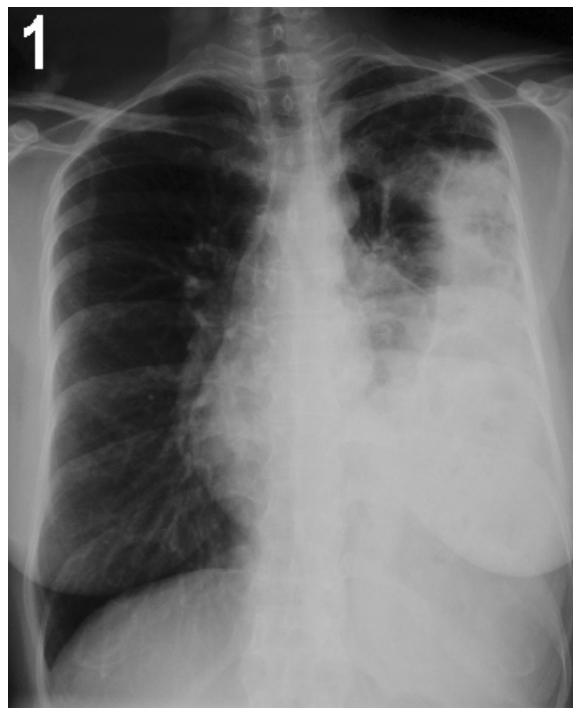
Chest radiograph PA view showing raised left hemidiaphragm and presence of air filled bowel loops in the left thoracic cavity.
